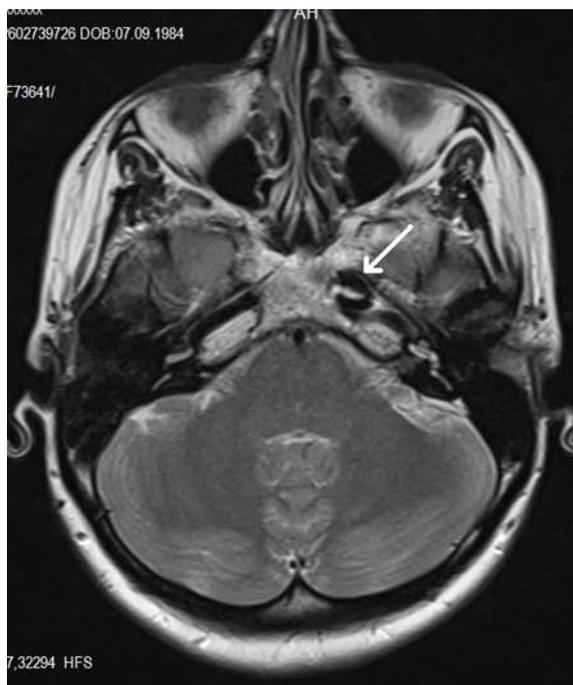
The axial image of T2-weighted sequence at the level close to the Dorello's canal. The distal part of the left ICA petrous segment had a remarkable loss of signal void in the central lumen (white arrow).
